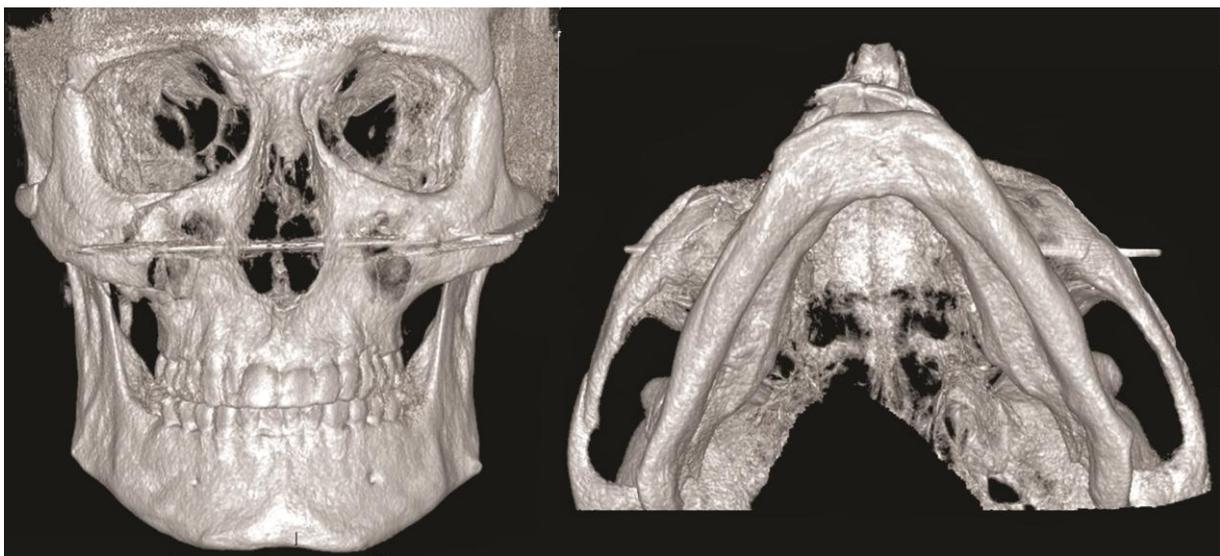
Transfacial Kirshner's wire, Facial CBCT 3D reconstruction.
